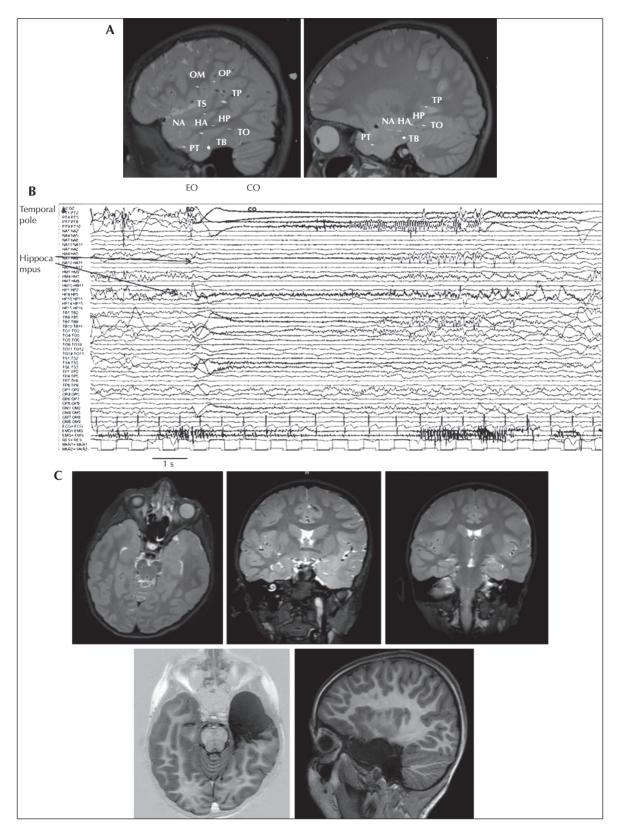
Patient 16. (A) SEEG with electrode implantation scheme (left: lateral view; right: hippocampal view). (B) Ictal SEEG (see video sequence 5) showing the ictal discharge almost restricted to the temporal pole. EO: electrical onset; CO: clinical onset. (C) Preoperative MRI showing left temporal pole blurring without hippocampal sclerosis and postoperative follow-up.
